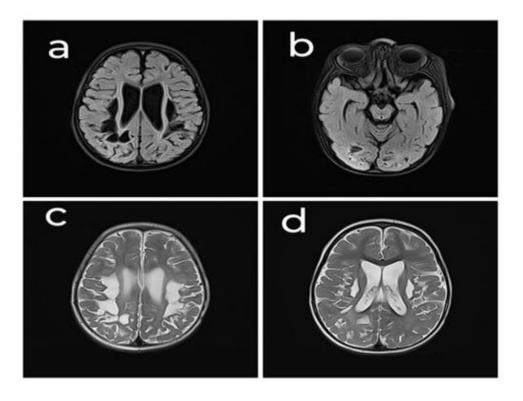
Image a & b Axial FLAIR images showing symmetric large gliotic areas with encephalomalacia in bilateral parietal lobes and cerebellum. c & d Axial T2W images showing encephalomalacia in bilateral parietal lobes and bilateral basal ganglia
